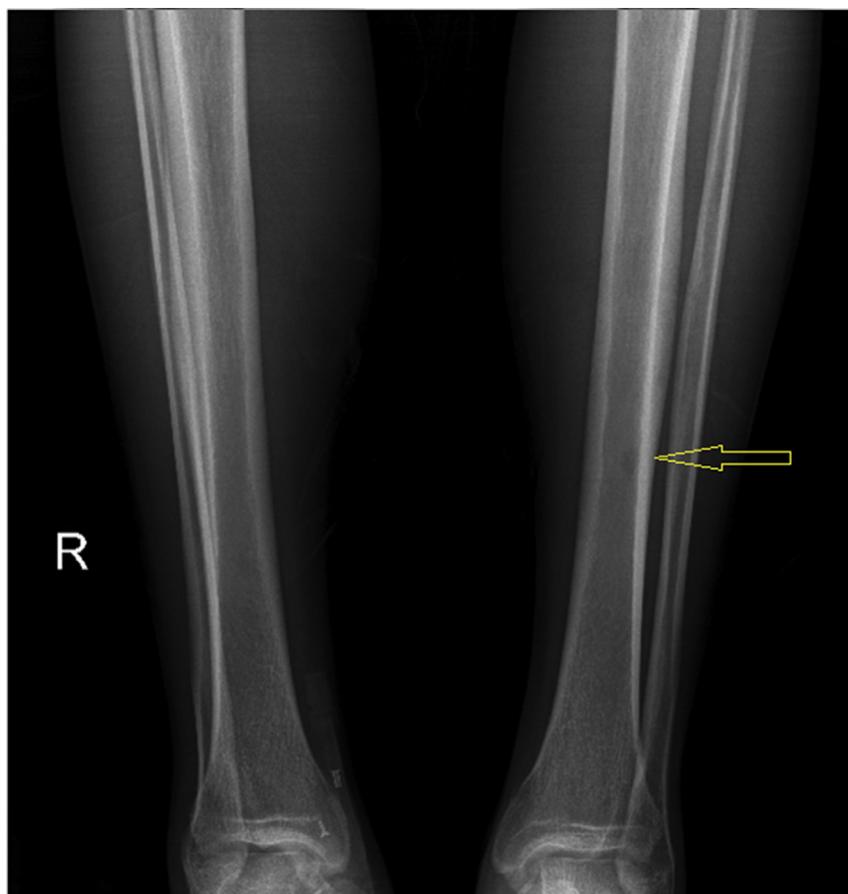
X-ray imaging showing moth-eaten bone destruction and periosteal proliferation in the left tibia.
